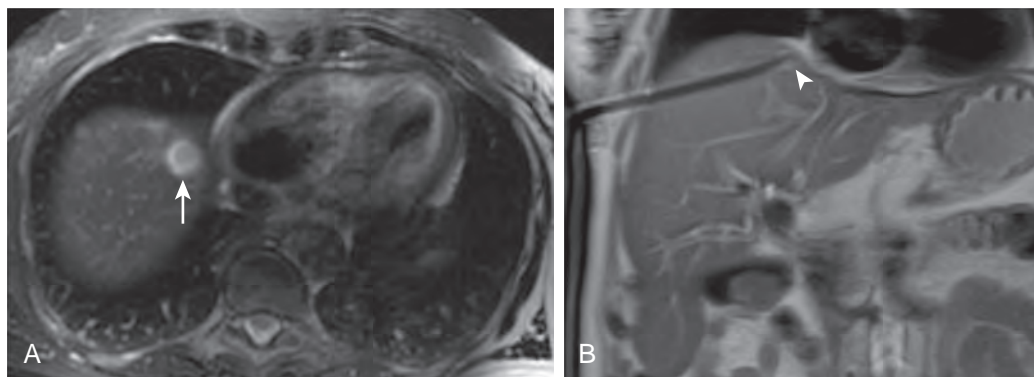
MRI of a 76-year-old woman with ampullary carcinoma. A. Axial T2-weighted MRI demonstrates a 1.2-cm T2 hyperintense lesion in the hepatic dome (arrow). B. Coronal MRI demonstrates the biopsy needle within the hepatic dome lesion (arrowhead). Given its multiplanar capabilities, MRI facilitates biopsy of lesions that would be difficult to target by conventional axial approaches. Fine-needle aspiration revealed hepatocytes with focal chronic inflammatory cells.
